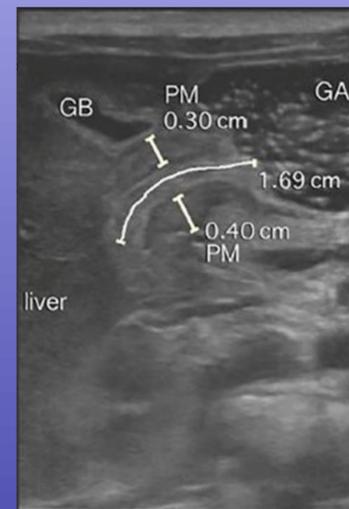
Shows the long axis of an ultrasound which shows the thickened, elongated pyloric channel. The pyloric muscle (PM) thickness is greater than 2mm on either side of the pyloric channel which proves this is a pathological condition.⁷
